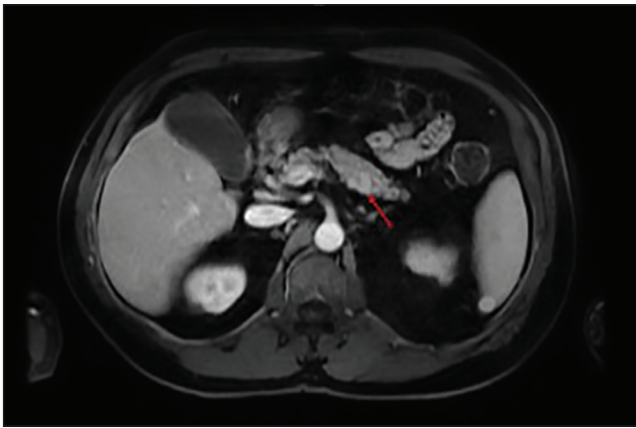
MRI (cross-sectional view) (arrow) showing T2-weighted hypointense lesion within the pancreatic body
